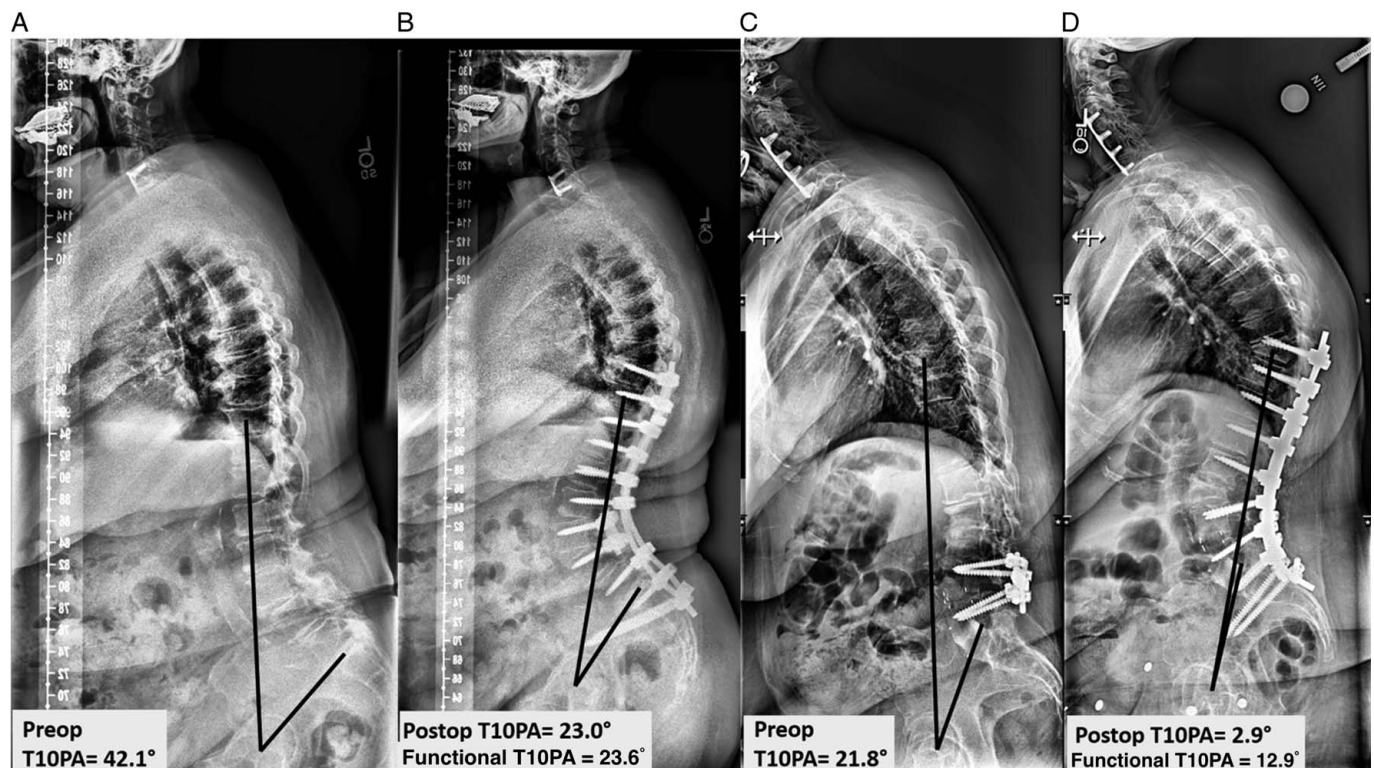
(A) Preoperative and (B) postoperative radiographs of a 60-year-old patient that was corrected to functional alignment based on T10PA and did not develop PJK. (C) Preoperative and (D) postoperative radiographs of a 64-year-old patient that was overcorrected (T10PA offset = 10°) and subsequently developed PJK. PJK indicates proximal junctional kyphosis; T10PA, T10-pelvic angle.
